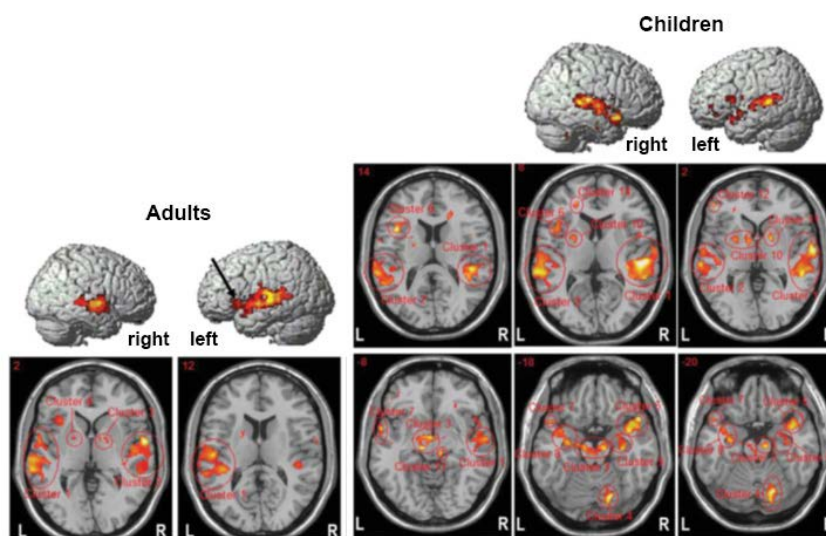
Clusters for the MST in adults (left) and in children (right) on selected axial T1-weighted images and the lateral view of the brain. Adults (left side): note large clusters present located in the STG, with extensions running to the MTG, the end of the temporal cortex, the insula (clusters 1 and 2) and the IFG. Children (right side): clusters present located in the temporal lobe, including the STG and MTG (clusters 1, 2, 5, and 7). Clusters were also found in the frontal lobe, each activating parts of the IFG, including BA 44 and 45 (clusters 6 and 12), and with extensions running to the insula (cluster 6). Also, activation of the limbic system (hippocampal area) of both hemispheres (clusters 8 and 9).⁴
